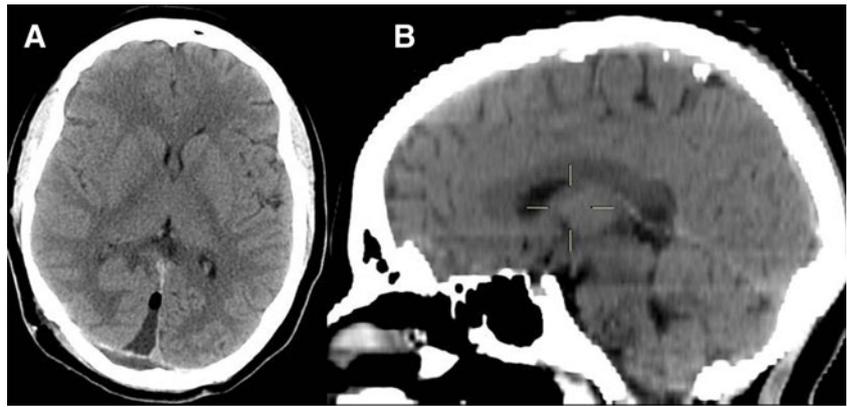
Axial (a) and sagittal reconstruction (b) of the immediate postoperative CT scan confirming the excision of the cyst. The surgical route is still evident as consequence of the retraction of the right occipital lobe (a)
